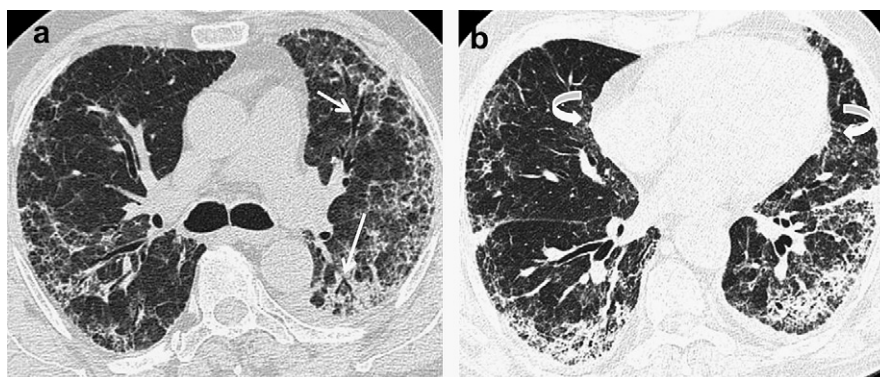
a, b Initial HRCT in the upper (a) and lower lung fields (b) respectively, shows a reticular pattern of lesions in the peripheral third of both lungs, irregular interfaces and interlobular septa thickening, traction bronchiectasis and bronchiolectasis (arrows) and patchy areas of ground glass attenuation (curved arrows).
